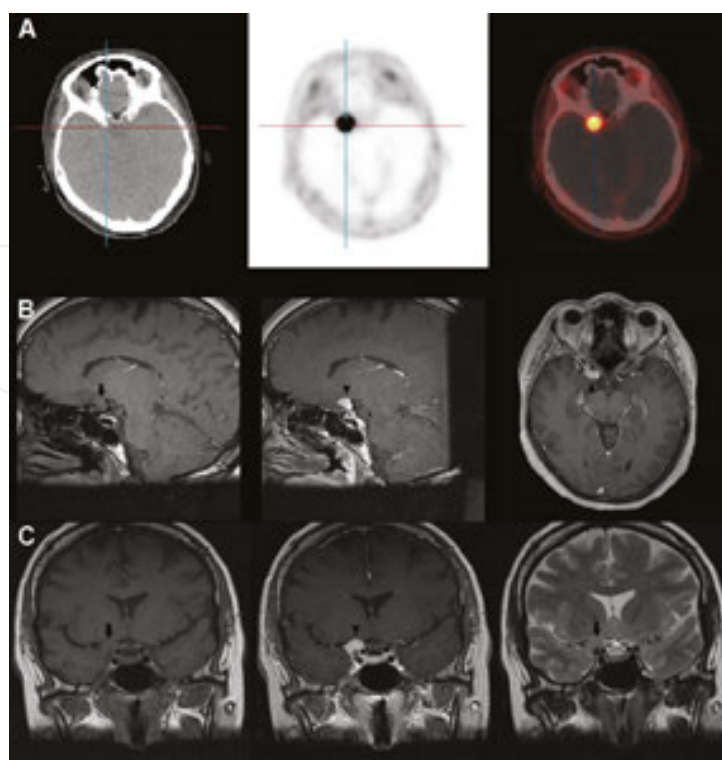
Row A: Fusion PET/CT shows a Ga-68 DOTATATE-avid focus directly adjacent to the right anterior clinoid process of the sphenoid bone. Rows B and C: Multiplanar MRI sequences show characteristic features of an intracranial meningioma on non-enhanced (arrows) and gadolinium-enhanced (arrowheads) imaging.
